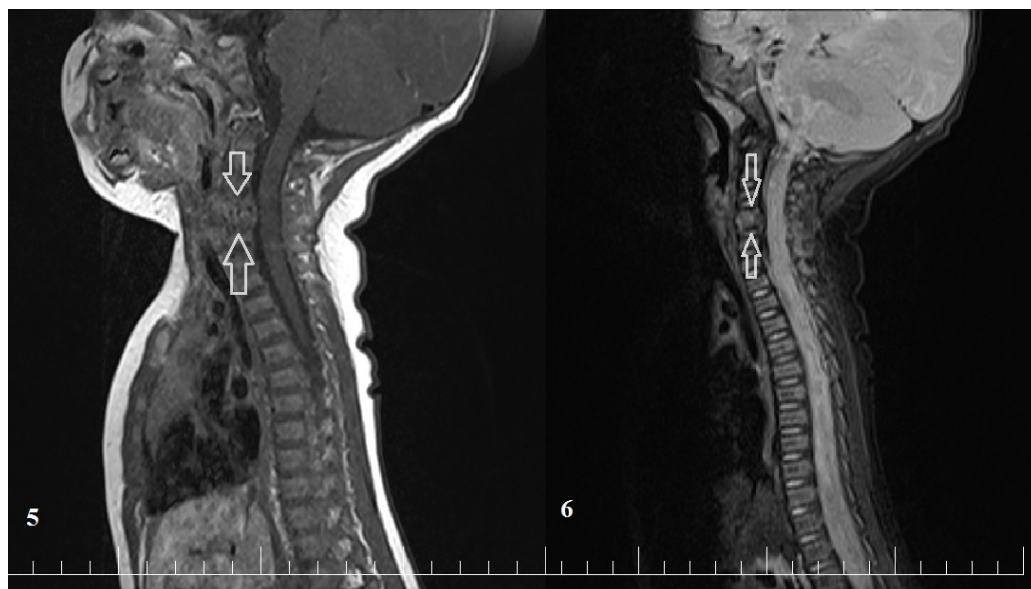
T1-weighted +contrast sagittal MRI reveal resolution of the inflammation present before at the level of C5 and C6 vertebral bodies(white arrows). At this time of examination, C4 and C5 vertebral bodies seems to be fused, seen as a single bone structure.
